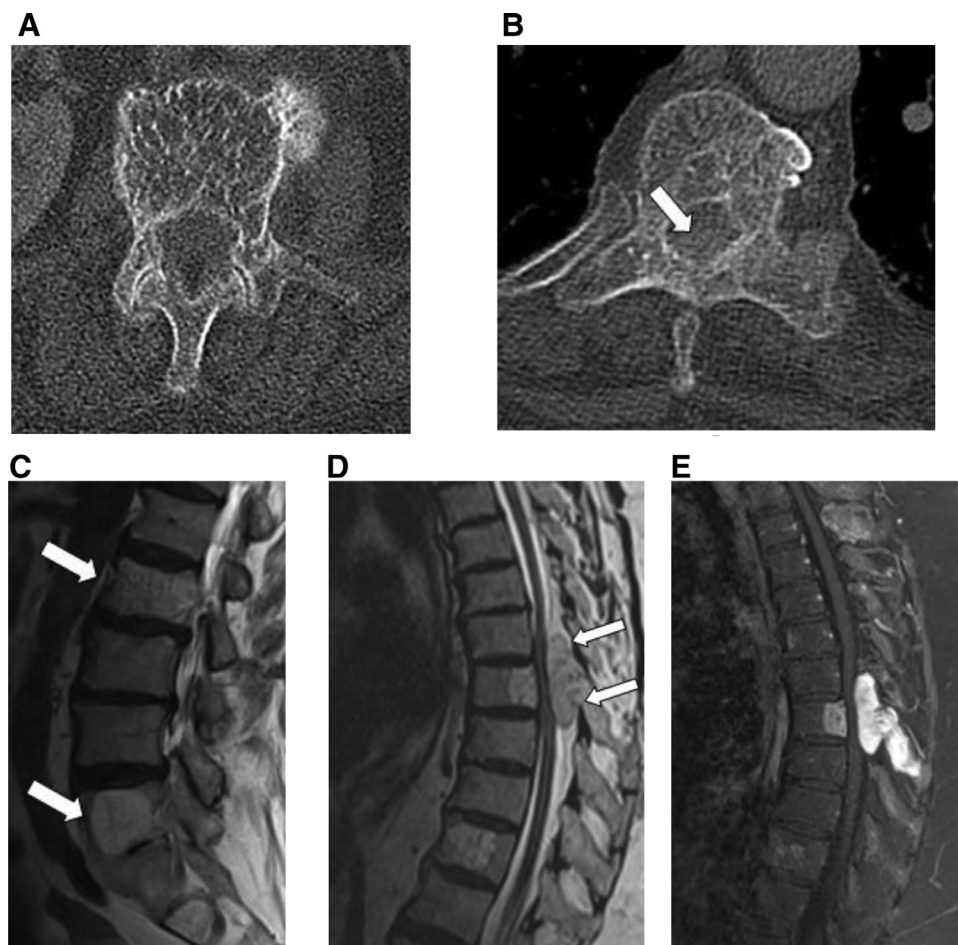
(A). “Polka-dot” sign in which cross section of the vertebra on axial CT shows foci of high density owing to trabecular thickening, a finding characteristic of hemangiomas. (B) Axial CT evaluation of the lesions at T7-T8 shows an epidural soft tissue component (arrow) concerning for metastasis. (C) Sagittal T2WI MRI shows multiple high T2 signal osseous lesions (arrows). The high signal, particularly on T1WI, is mainly attributed to the fat content and may vary according the proportion of fat and vascular tissue. (D) Sagittal T2WI MRI shows the posterior epidural component at T7-T8 (arrows) with consequent severe cord compression. (E) Sagittal postcontrast T1W FS MRI shows intense enhancement of the T7-T8 lesion.
